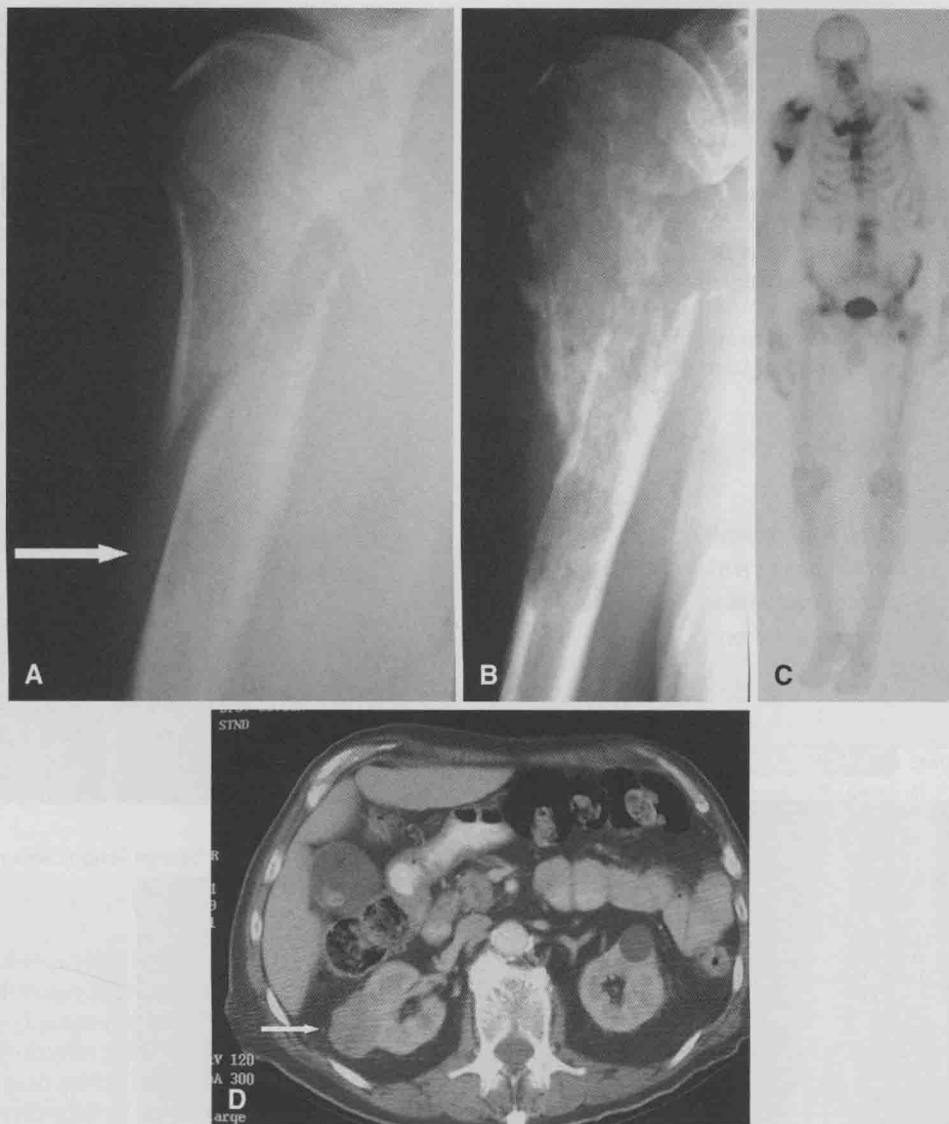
Humeral fracture after minimal trauma in 81-year-old man with no known history of malignancy. A, Lesion (arrow) was not identified initially, and patient was treated conservatively at another institution. B, Radiograph 10 weeks after injury shows progression of malignant process. Patient was referred to orthopaedic oncology center, where most likely diagnosis was thought to be either multiple myeloma or metastatic carcinoma. C, Bone scan reveals multiple sites of disease. D, CT of abdomen reveals lesion in the right kidney, which proved to be primary lesion (arrow).
